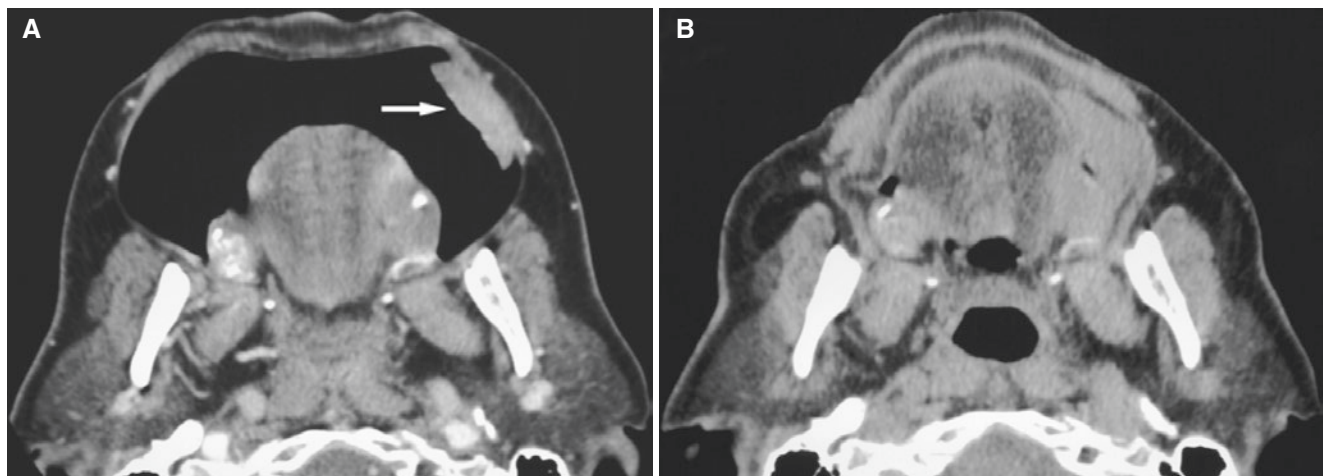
Squamous cell carcinoma of cheek with and without blowing cheek; 74-year-old male with lump in cheek. (A) Axial CT image with blowing cheek shows soft-tissue tumor in buccal mucosa (arrow). (B) Axial CT without blowing cheek cannot reveal origin of tumor
